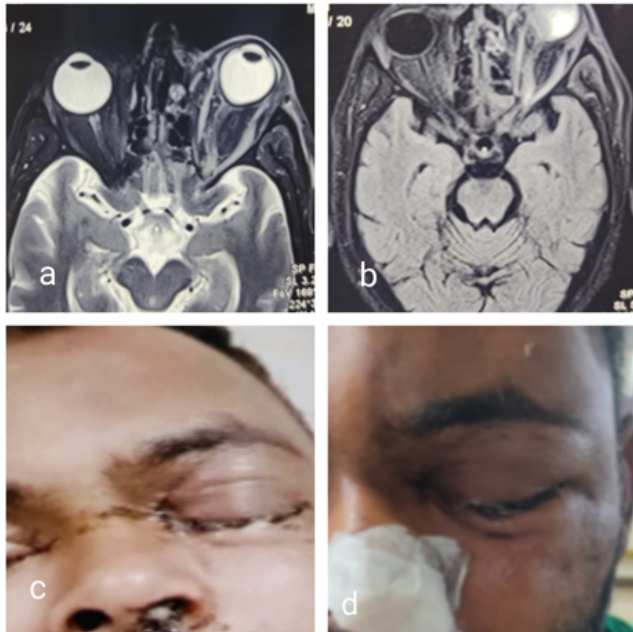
a,b: Repeat MRI showed intraconal along with extraconal and preseptal involvement; c: pre FESS; d: post FESS.
